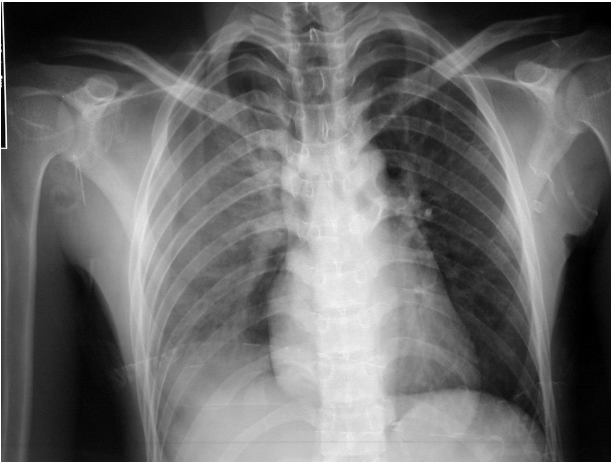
Chest X-ray. Radiogram was taken in supine position. Massive hemothorax in the right chest is evident.
